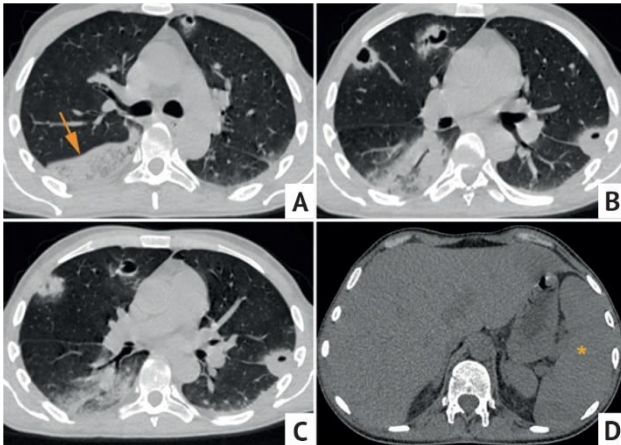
Axial chest CT images (A–D) of a 34 y.o. patient with IE complicated by SPE. Small subpleural infiltrates and forming cavities. An extensive heterogeneous opacity in the right lower lobe (arrow) without the air bronchogram sign, which is more likely display a lung infarction site. Also note the enlarged spleen (\*) which is also characteristic of the septic process
